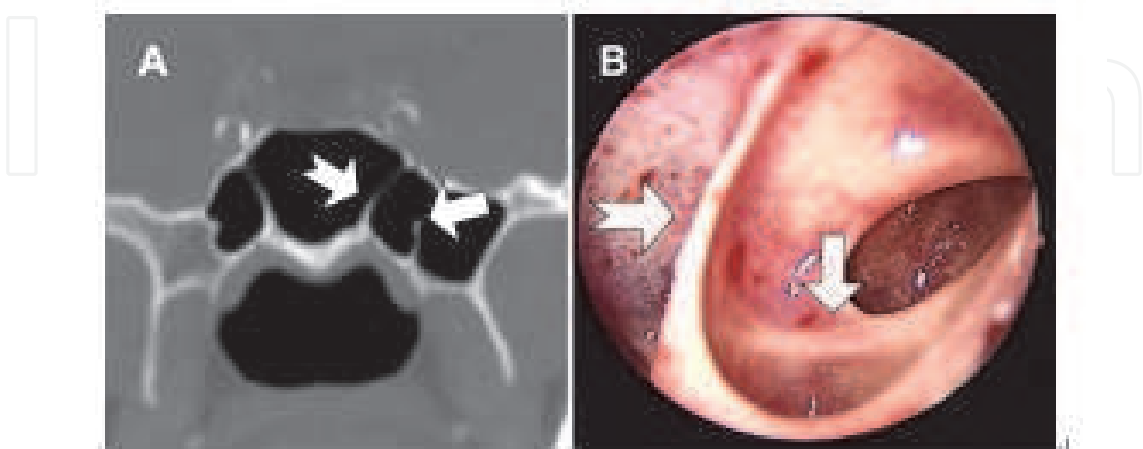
The intra-sphenoid septum is demonstrated on A: Coronal CT slice; B: intraoperative endoscopic view. Arrows indicate vidian canal; the bifid tail arrow indicates the intra-sphenoid septum
